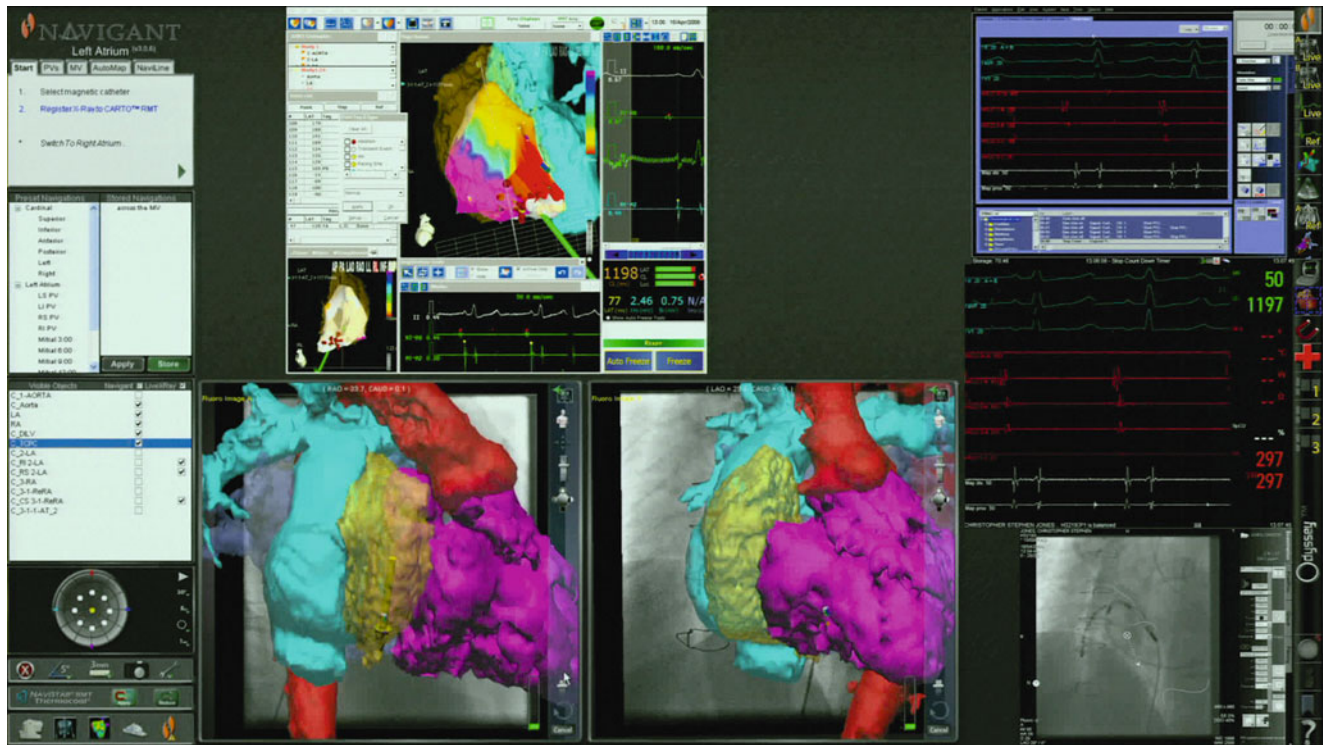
Image integration of previously acquired 3D magnetic resonance imaging and superimposition on the magnetic navigation workstation Odyssey (Stereotaxis Inc.)
